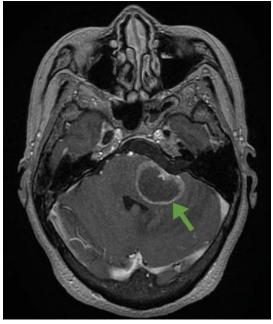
T2-weighted magnetic resonance imaging with contrast revealed a cystic enhancing lesion in the left middle cerebellar peduncle (arrow).
